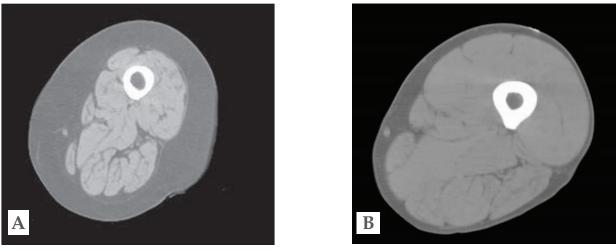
Cross-sectional MRI of the mid-thigh of a sedentary 67-year-old (A) and an active 23-year-old individual (B). Note the relative decrease in muscle mass and increase in fat mass in the older individual. Images courtesy of Miriam Nelson, PhD.
